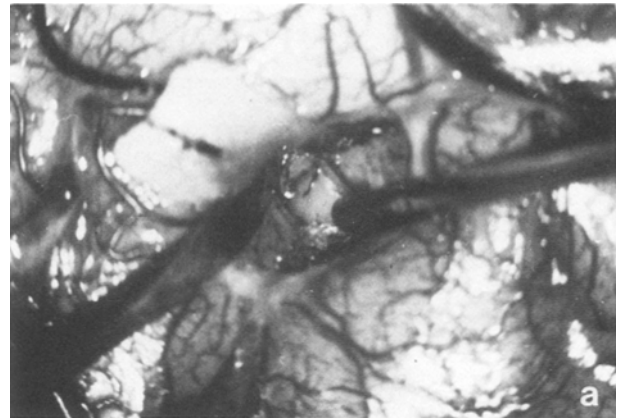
Astrocytoma III at the end of F_2 (M. W. 110238/1982), partial gyrectomy, integral approach between F_2 and F_3 (a), complete isolation of the end of F_2 (b), defect after removal with tumour (c), post-operative CT (d), infrequent fits over 1½ years
